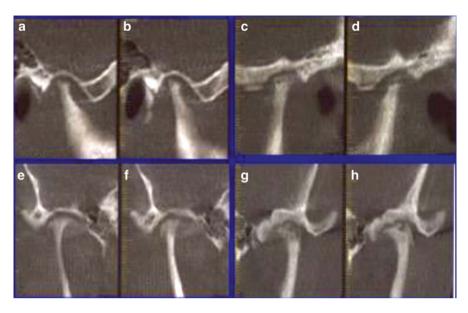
Case 1: Presurgery sagittal and coronal images (cone beam CT) of bilateral TMJs demonstrating advanced arthritis as a result of untreated AICR. (a and b) right TMJ, (c and d) left TMJ sagittal view, (e and f) right TMJ, (g and h) left TMJ coronal views
